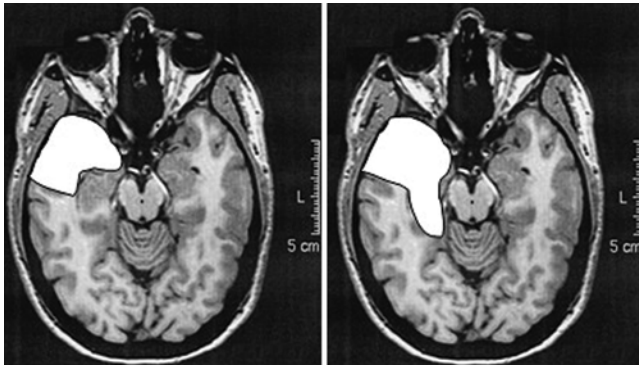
Axial MR images showing the extension of resection in apical resection (*left*) and in anterior temporal lobe resection (*right*).
